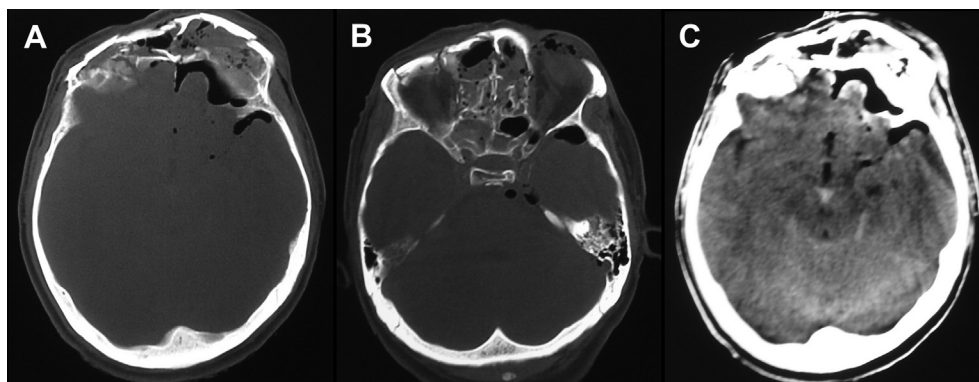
Pre-operative CT images showing extensive comminuted fractures involving frontal bone, anterior and posterior table of frontal sinus and anterior cranial base with patchy frontal contusions and pneumocephalus.
